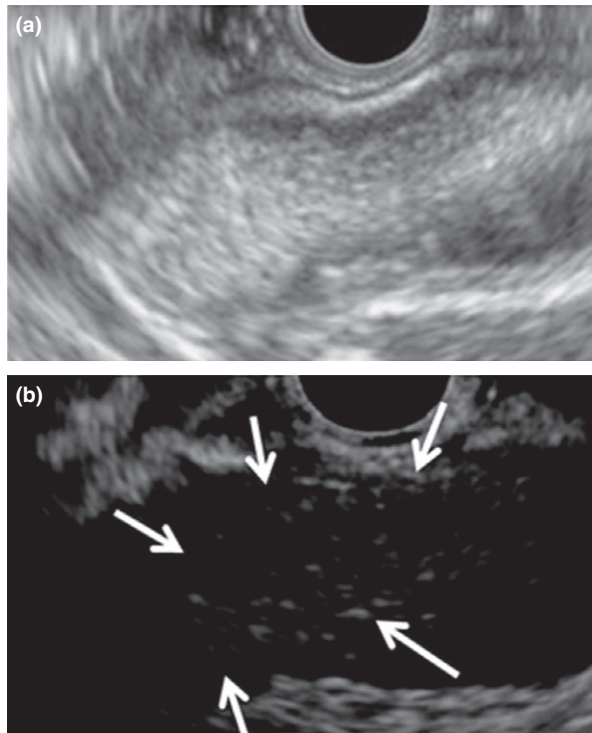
Typical case of gallbladder sludge plug. (a) Fundamental B-mode endoscopic ultrasonography (monitor mode). A high echoic structure can be seen in the gallbladder. (b) Contrast-enhanced harmonic endoscopic ultrasonography. The lesion is not enhanced (arrows).
